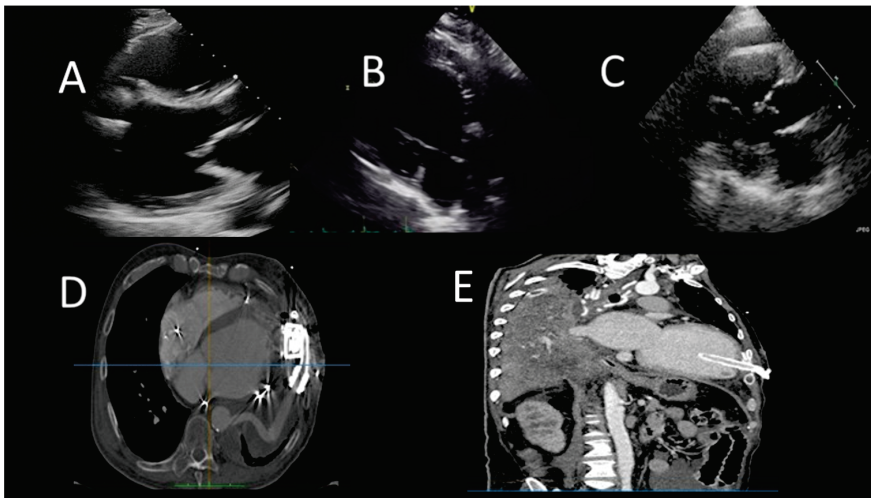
Evaluation after left ventricle assist device (LVAD) (A) Transthoracic echocardiography (TTE) evaluation parasternal long axis (PLAX) shows normal position of interventricular septum (IVS) and the inflow cannula; (B) TTEPLAX view of LVAD patient, showing incorrect right-convex position of the interventricular septum; (C) TTE evaluation (PLAX) of LVAD patient, showing incorrect left-convex position of the IVS; (D) Cardiac computed tomography (CCT) showing hematoma around LV cannula; (E) CCT showing small left ventricular apical thrombus.
